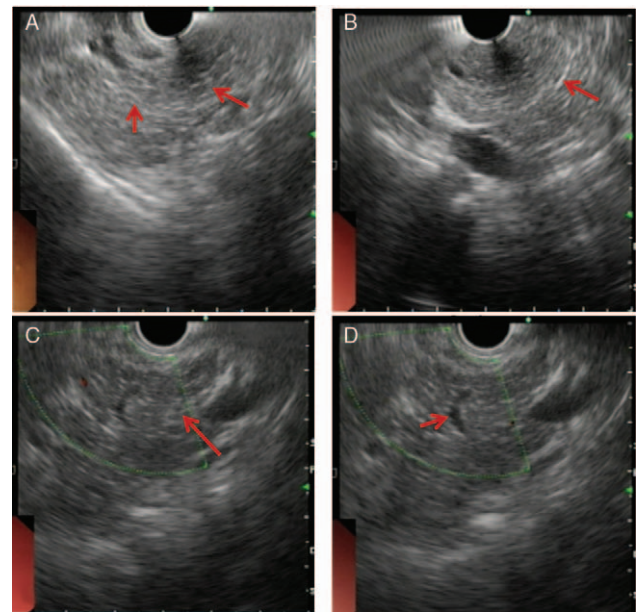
(A) EUS image showing hyperechoic foci (arrow). (B) EUS image showing hyperechoic strands (arrow). (C) EUS image showing parenchymal lobules (arrow). (D) EUS image showing hyperechoic duct wall (arrow). EUS = endoscopic ultrasound.
